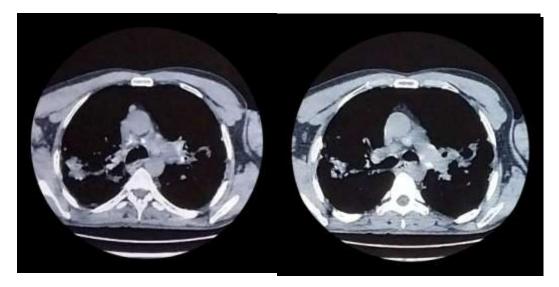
(B): Thoracic computed tomography (mediastinal window) non-compressive bilateral mediastino-hilar adenopathy, the majority of which are calcified, the largest of which is located in the 4R chain, measuring 15mm in minor axis
